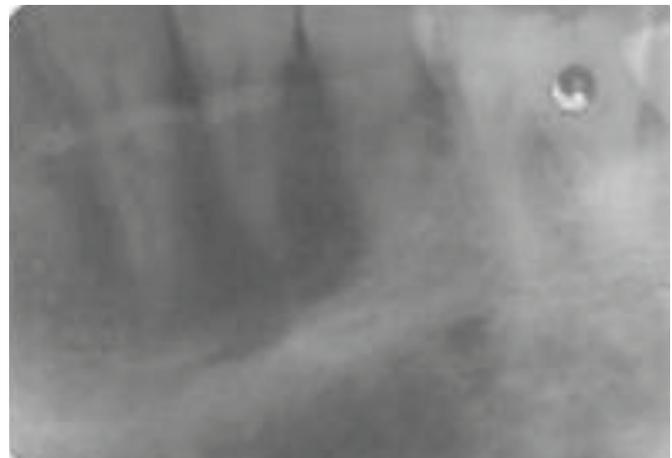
Intraoral periapical – 44, 45, 46
